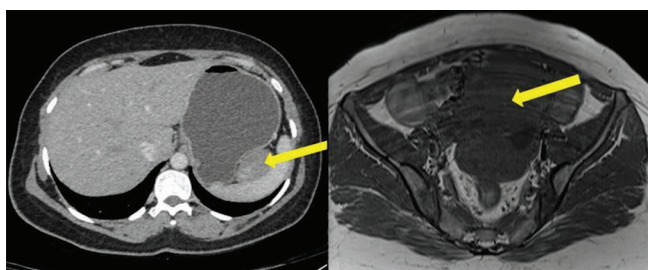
Axial CT in the arterial phase shows a similar lesion in the left hypochondrium adjacent to the spleen. Figure-4: Axial T1 weighted MR image shows hypointense mass lesions in the pelvis.
